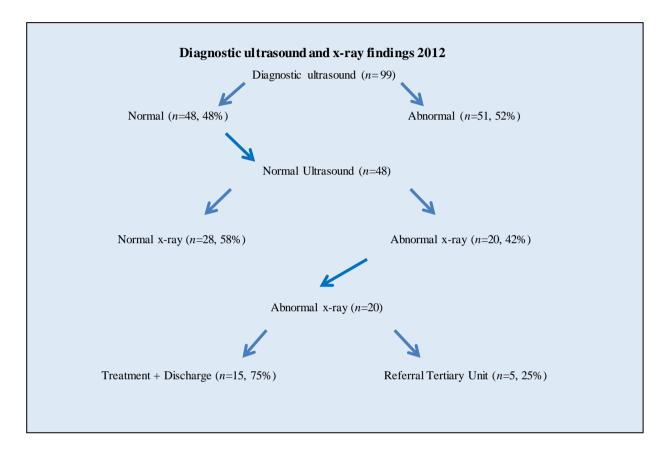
Diagnostic ultrasound and x-ray findings 2012
